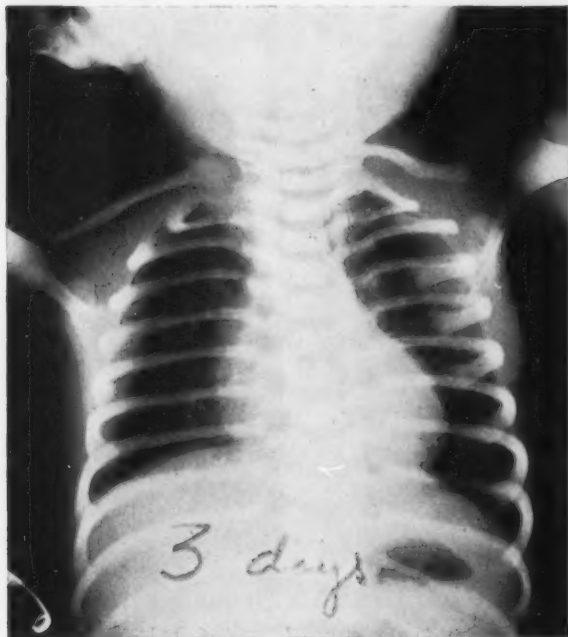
X-ray showing appearance of chest three days after bronchoscopy.
